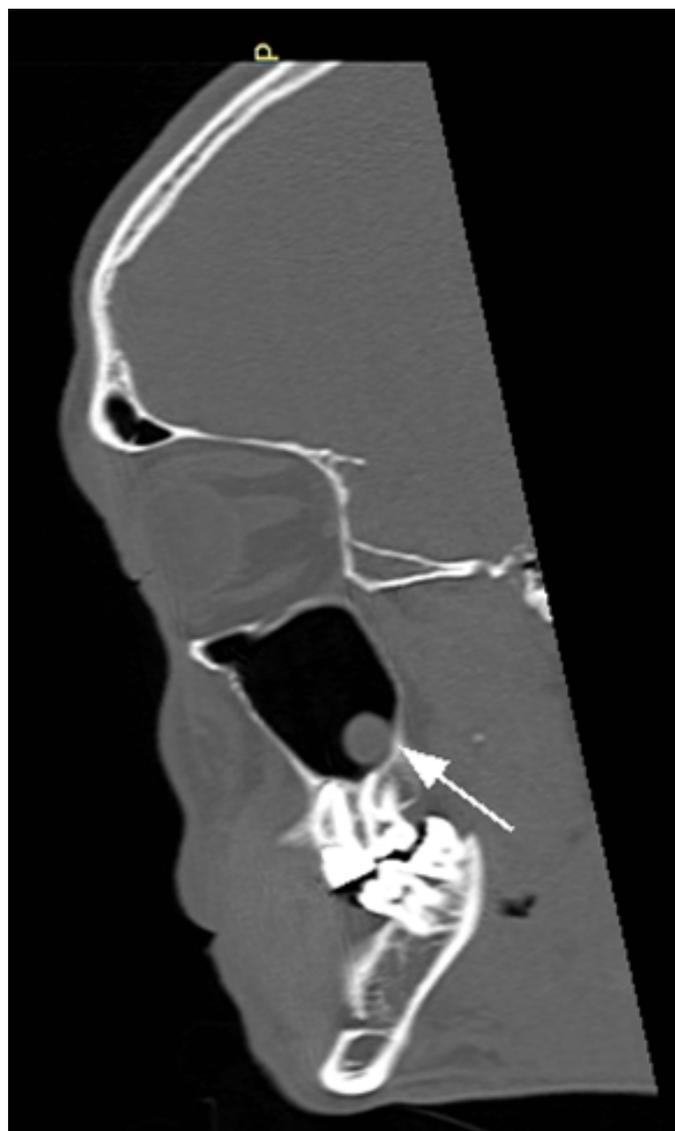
Follow-up sagittal computed tomography image. The arrow shows a small mucous retention cyst.
